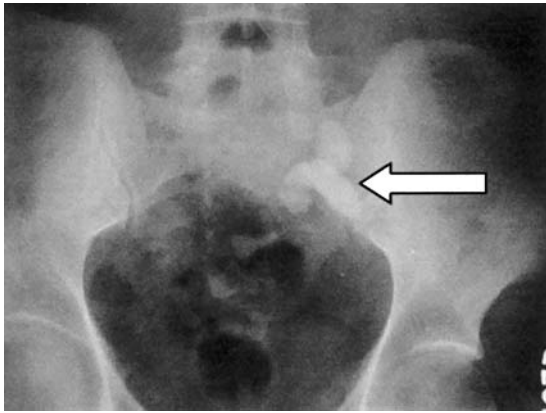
X-ray KUB showing stones in the ectopic left pelvic kidney overlying the left ala of the sacrum.
